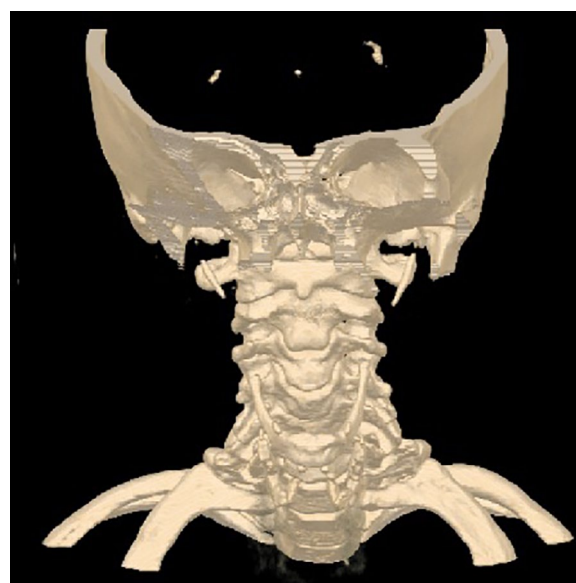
Three-dimensional reconstruction of computed tomography images. A transverse view showed the elongated left styloid process.
